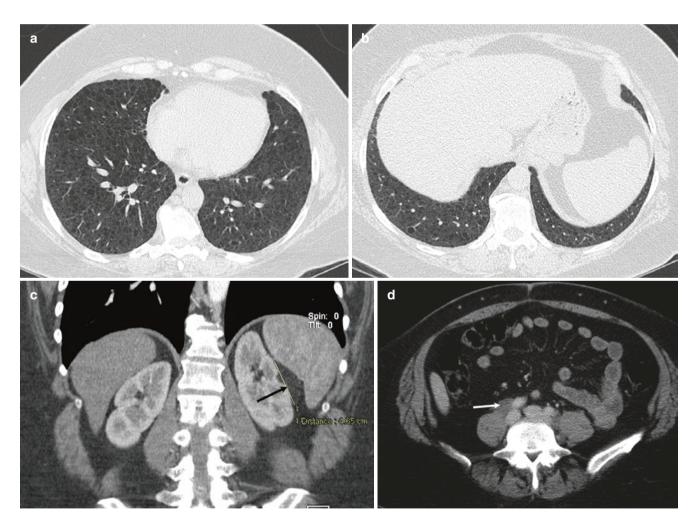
A 38-year-old woman with LAM. (a, b) Axial CT images show innumerable small uniform round cysts in both lungs extending in costophrenic angles. (c) Coronal CT image of the abdomen shows a
